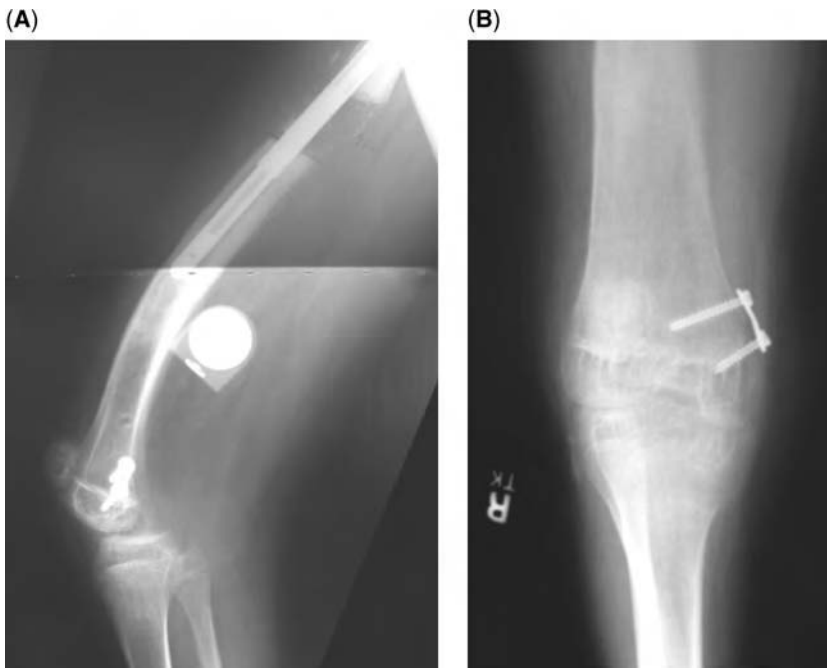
Patient with congenital femoral deficiency undergoing femoral lengthening with an intramedullary lengthening nail. Lateral view (A) and anteroposterior view (B) radiographs show knee flexion contracture with concurrent posterior-lateral subluxation. Aggressive therapy and soft tissue releases can be used to solve this complication. If an external fixator is being used for lengthening with this complication, lengthening is halted immediately. Fortunately, the intramedullary nail had completed the programmed 5 cm of lengthening at the time this radiograph was obtained.
